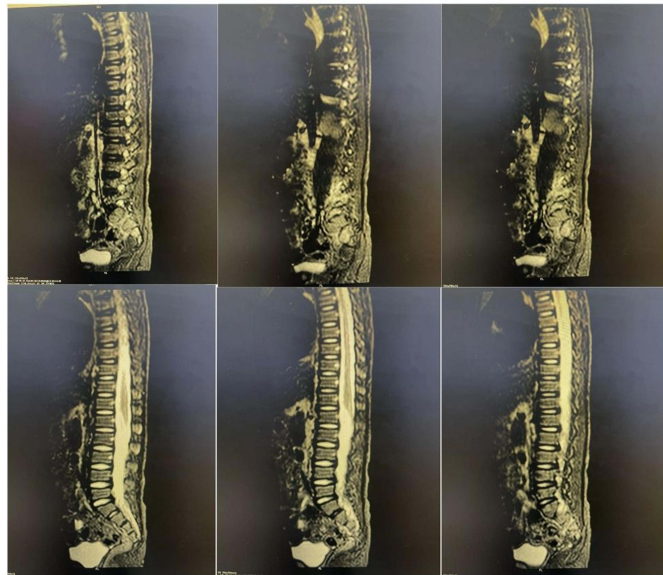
Diagnostic Evaluation, including: Panel (A) CT head demonstrating no acute intracranial abnormality, Panel (B) MRI spine demonstrating normal spinal cord and vertebral structures.
